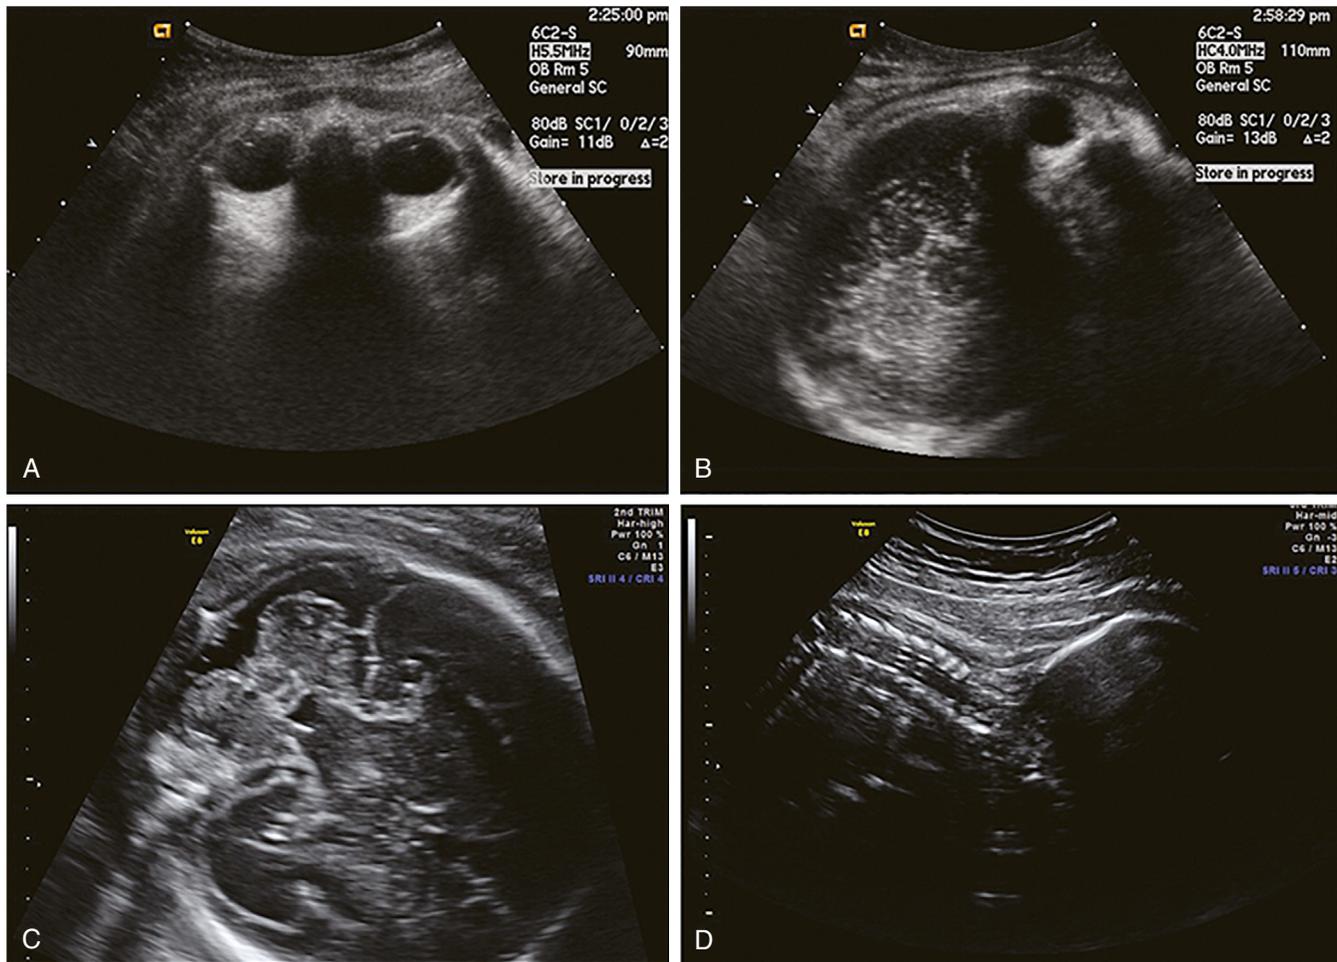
Transabdominal Ultrasound Determination of the Fetal Occiput. A, Direct occiput posterior with both fetal orbits facing the transducer. B, Right occiput posterior with the fetal orbits facing anteriorly to the maternal left. C, Right occiput anterior with the fetal cerebellum seen anteriorly to the maternal right. D, Occiput anterior by localization of the fetal spine in the sagittal plane. (From Barth WH Jr. Persistent occiput posterior. *Obstet Gynecol.* 2015;125:695-709.)
